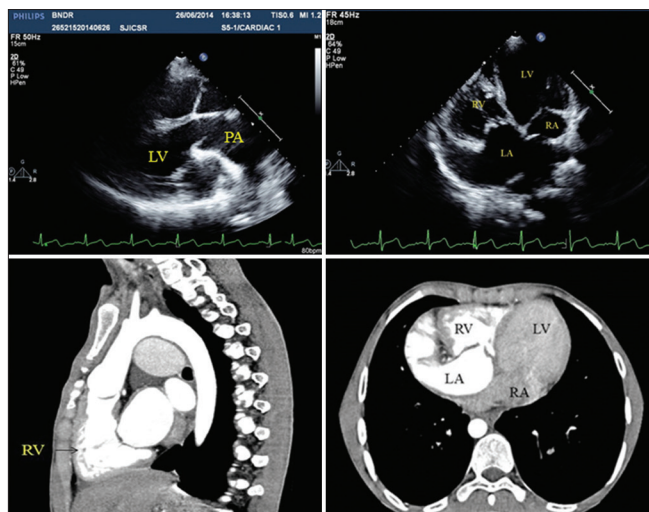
Pre-procedure imaging depicting the cardiac anatomy: Two-dimensional echocardiography and cardiac computed tomography highlighting atrioventricular and ventriculo-arterial discordance. In addition, thickening of systemic atrioventricular valve is appreciated. (RA: Right atrium, RV: Right ventricle, LA: Left atrium, LV: Left ventricle, PA: Pulmonary artery)
